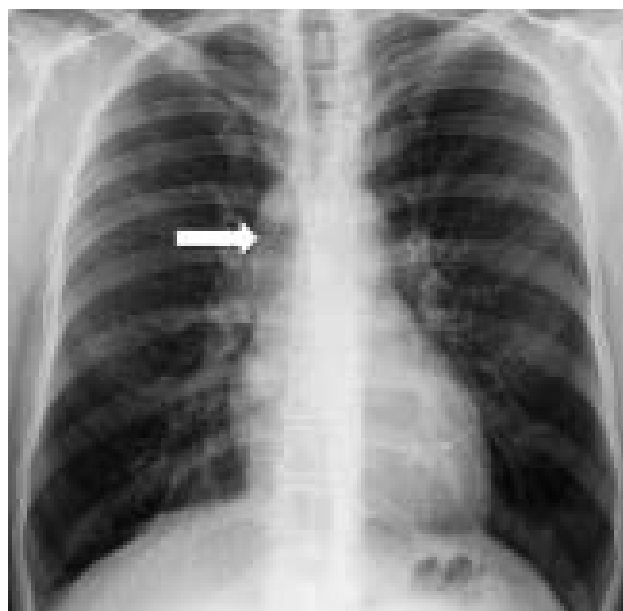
Chest radiography showing azygos vein dilation (white arrow).
